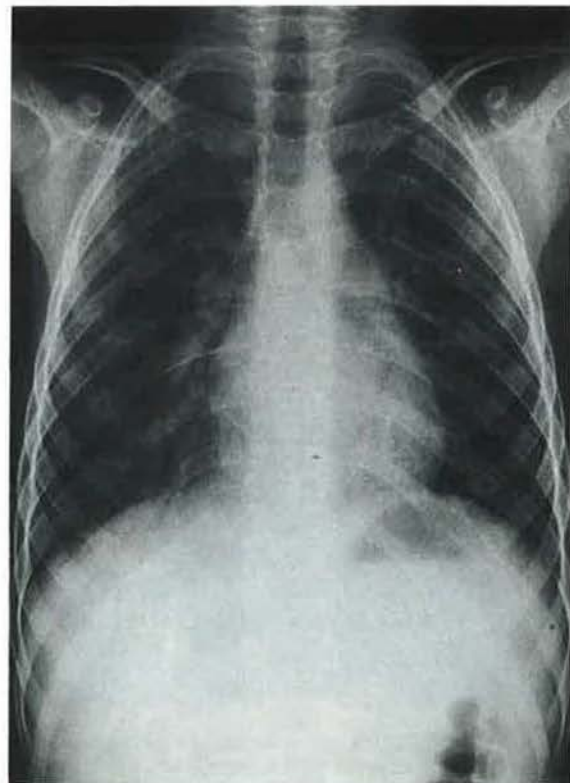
Chest X-ray at the time of diagnosis.
